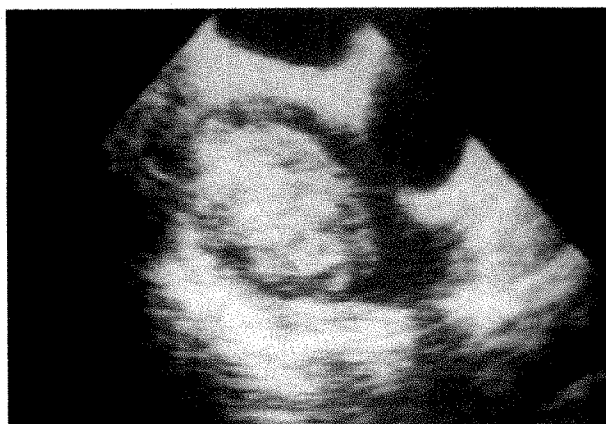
This 56-year-old man was first admitted in a different hospital, where an unresectable lung cancer infiltrating the right atrium had been diagnosed by computed tomography. He was sent for oncologic evaluation to our hospital, and underwent transesophageal echocardiography within the prospective study. Transesophageal echocardiography showed a 5 × 4 cm intracardiac mass limited to the right atrium, without any extracardiac extension. Surgery was then suggested: a benign angiotelioma was resected.
